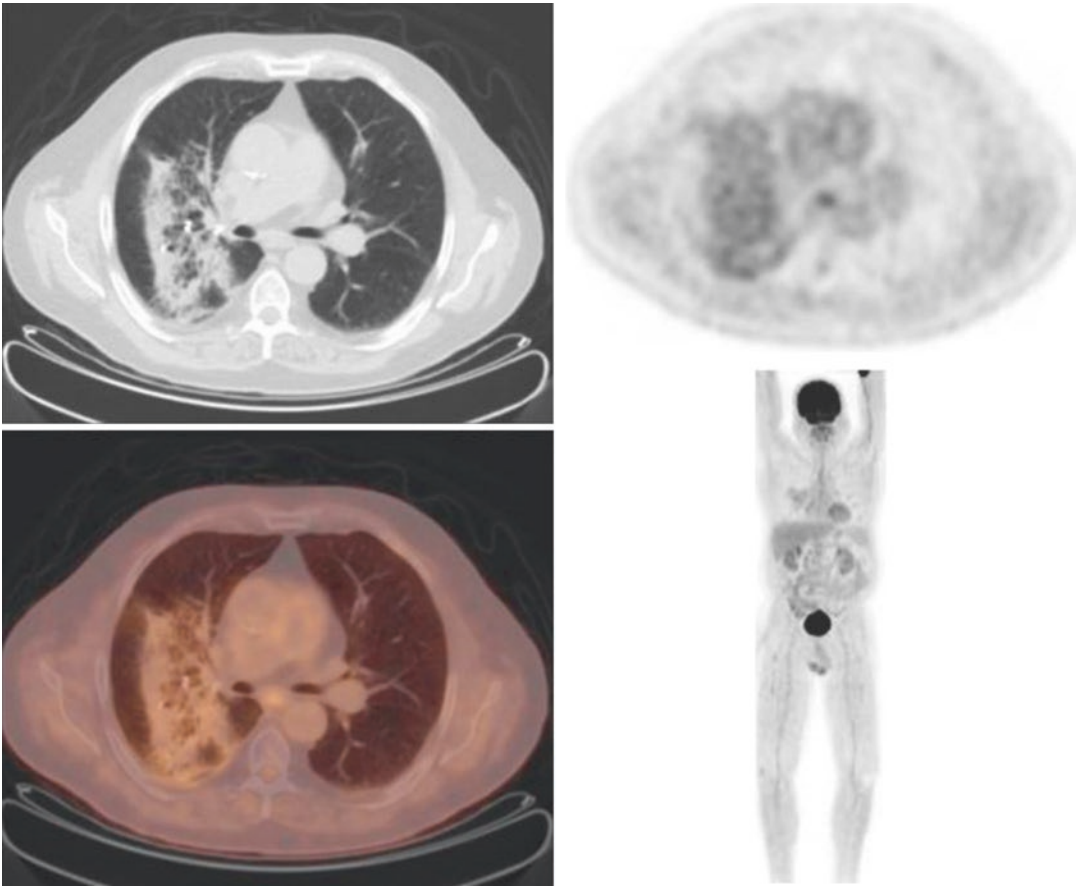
A 68-year-old male with a history of right upper lobe adenocarcinoma. PET/CT images following cyber knife treatment showing fiducial markers at the site
